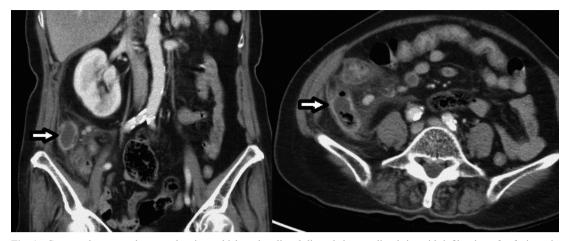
Computed tomography scan showing a thickened wall and distended appendiceal tip, with infiltration of soft-tissue in the ileocecal region suggestive of acute appendicitis.
